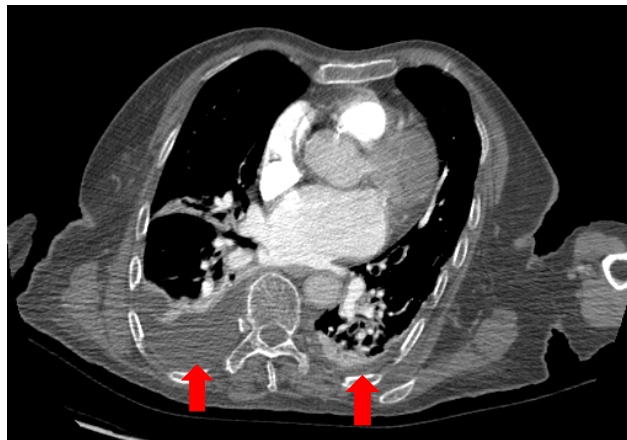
Axial computed tomography (CT) scan pulmonary window for 85 years old female demonstrating mild right and minimal left pleural effusion (red arrows) with adjacent pulmonary atelectasis
